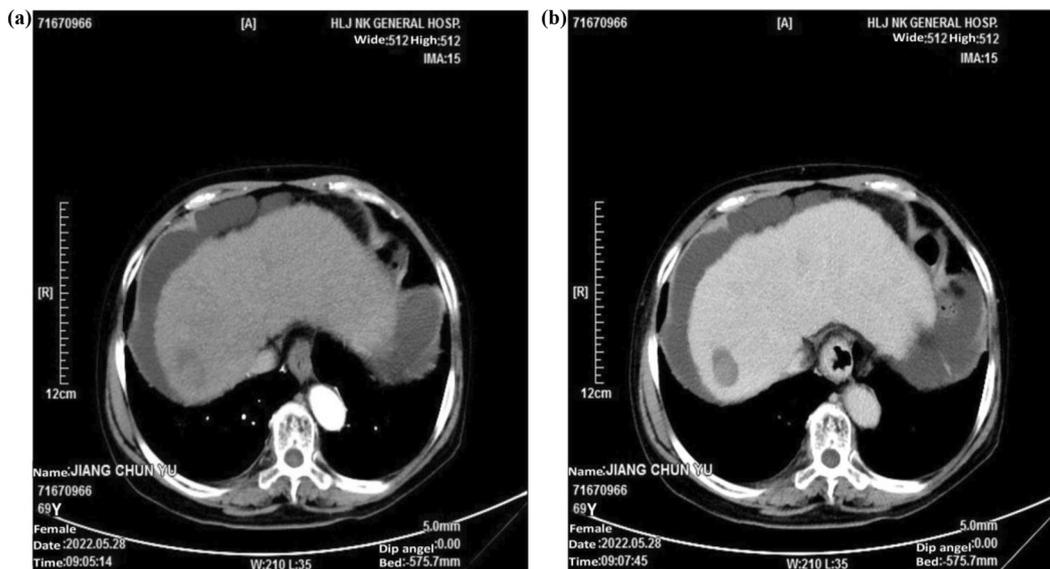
Liver enhanced computed tomography scan after treatment on May 28, 2022. (a) A size of about 18 mm × 29 mm low-density focus can be seen on the right lobe of the liver, with mild homogeneous enhancement in the arterial phase. (b) Slight patchy enhancement can be seen in the low-density focus in the liver portal phase, significantly lower than the surrounding liver parenchyma.
